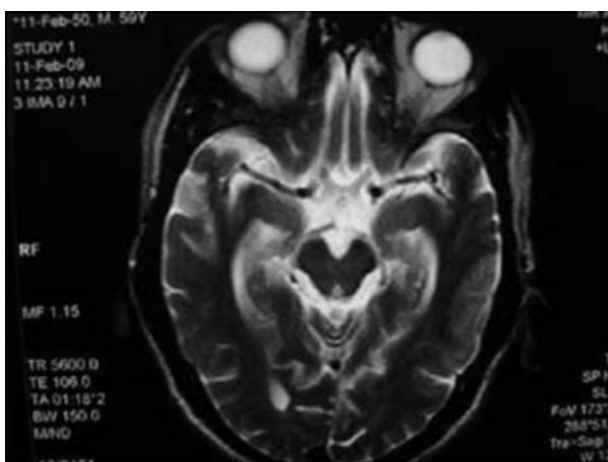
Magnetic resonance imaging after 6 months showed
